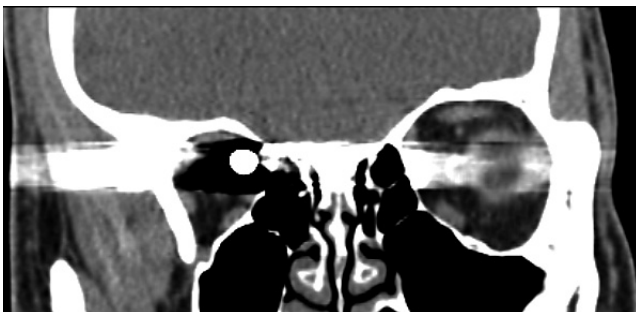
CT – frontal projection. Rear of the foreign body visible
